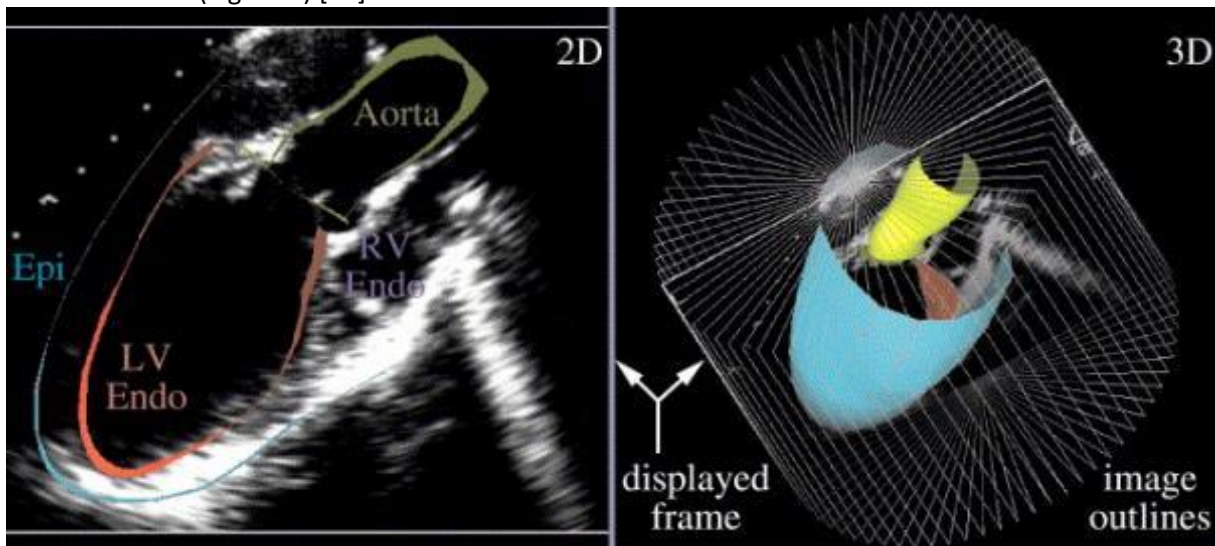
On the left panel the image captured by the ultrasound probe that was used to construct the 3D model with segmented surfaces, epicardial (Epi), Left ventricle endocardial (LV Endo), and Right ventricle endocardial (RV Endo). On the right panel the reconstructed 3D ventricular model. (Image taken from [19])
